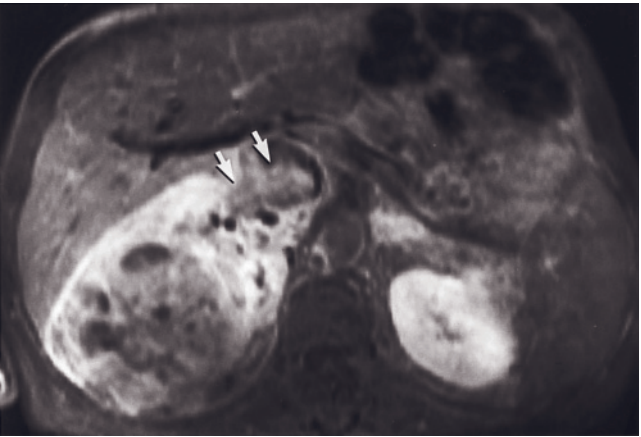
Renal cell cancer—Stage 3a. T1-weighted immediate (a) and 45-s (b, c) and transverse (d, e), coronal (f, g), and sagittal (h) fat-suppressed gadolinium-enhanced SGE images. A heterogeneous enhancing large renal cancer is present, which originates from the lower two-thirds of the right kidney. An enhancing tumor thrombus is seen within the right renal vein that extends into the inferior vena cava. Direct coronal (f, g) and sagittal (h) images permit evaluation of the superior extent of thrombus (arrow, f). Extensive vascular parasitization is appreciated (arrows, b) around the tumor. Dilated collateral lumbar veins are identified, one of which communicates with the IVC (arrow, e) at the level of the lower aspect of the thrombus. T1-weighted fat-suppressed
